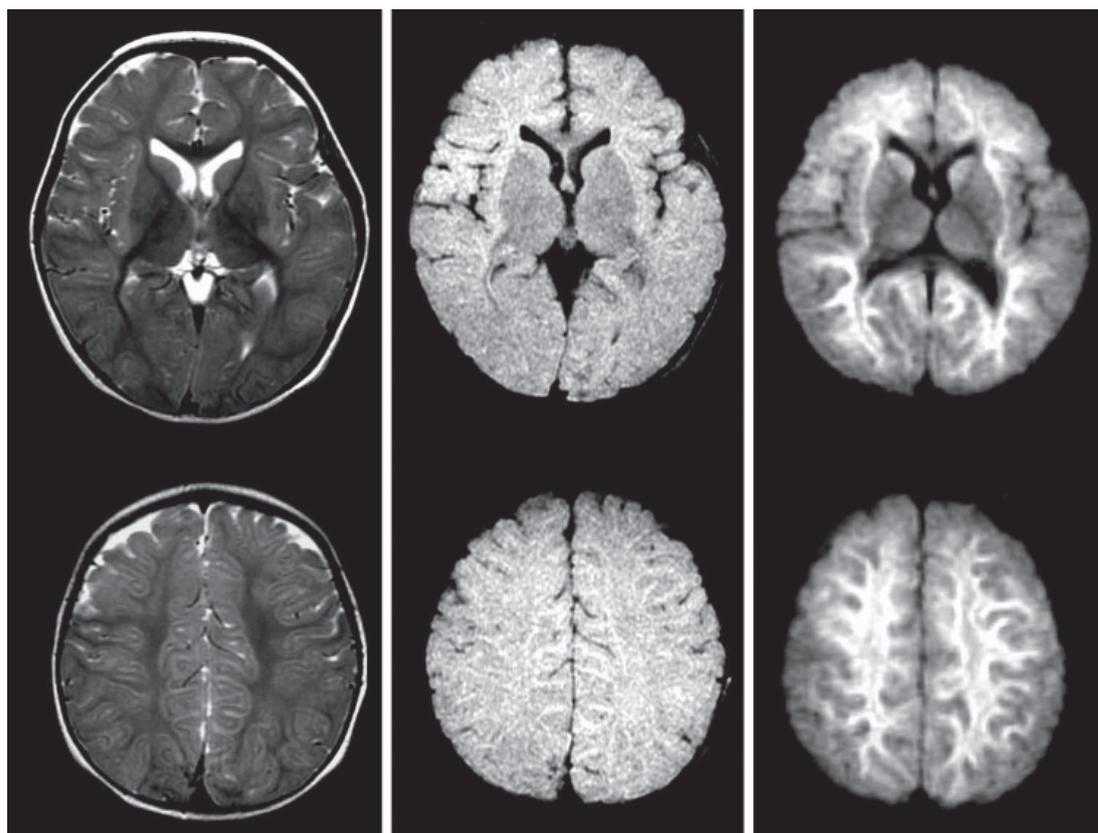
MRI on the 6th day. Left: T2 weighted image, middle: fluid attenuated inversion recovery (FLAIR), right: diffusion-weighted image. Note high signal areas in the cerebral white matter.
